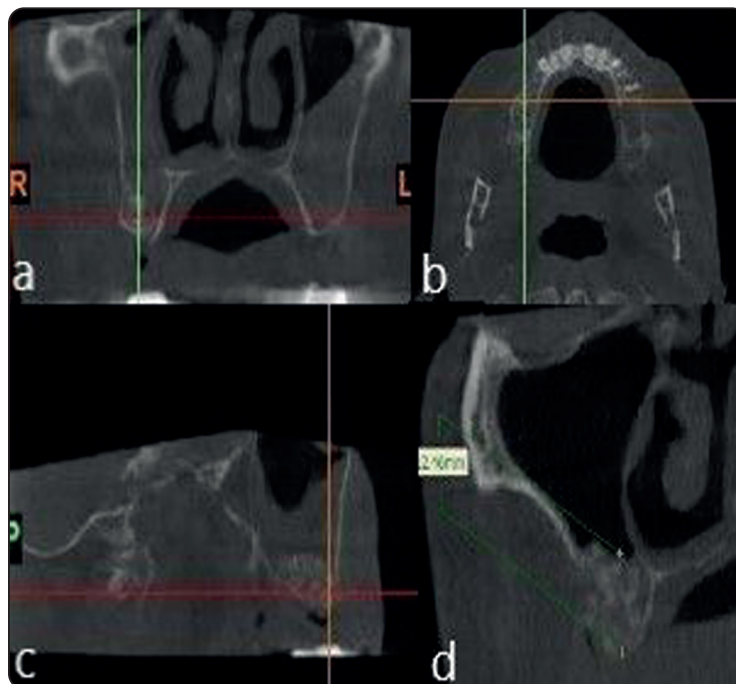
CBCT image revealing orientation line is adjusted on the Cross-sectional views A) Coronal B) Axial C) Sagittal D) Measuring the height on the coronal cut at 4 months postoperative
